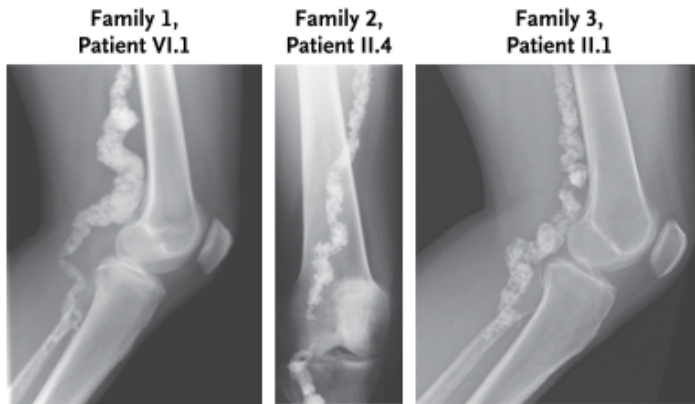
Radiographs of popliteal arteries of individuals from three different families. A similar phenotype is seen from the three distinct NT5E mutation types. ACDC is a painful condition that impairs mobility of the limbs. Symptoms typically begin when patients are in their 20s and progresses with age.
